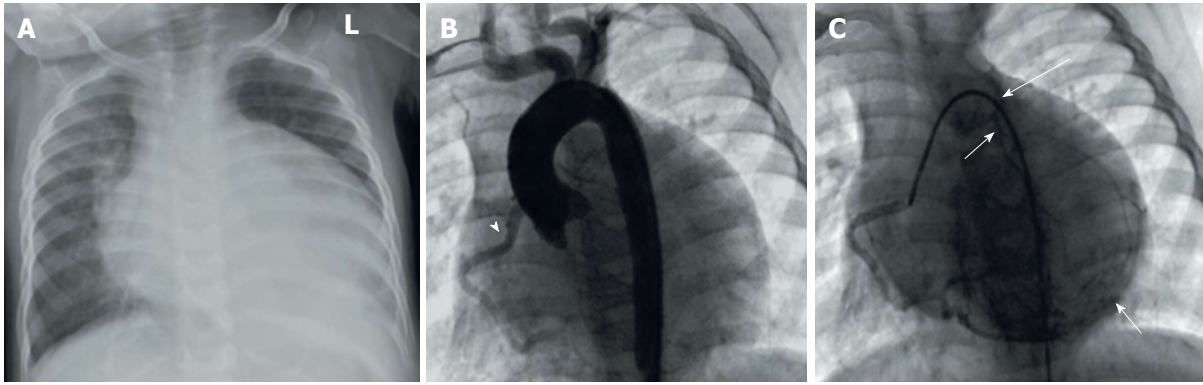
Anomalous origin of the left coronary artery from the pulmonary artery in infant. A: Cardiomegaly in chest X-ray; B: Aortogram showing only right coronary artery (RCA) originating from the aortic sinuses (arrowhead) but no left coronary artery; C: Selective angiography of RCA shows extensive collaterals from the RCA backfilling the left system and the pulmonary artery (arrows). Reproduced from ref. [74].
